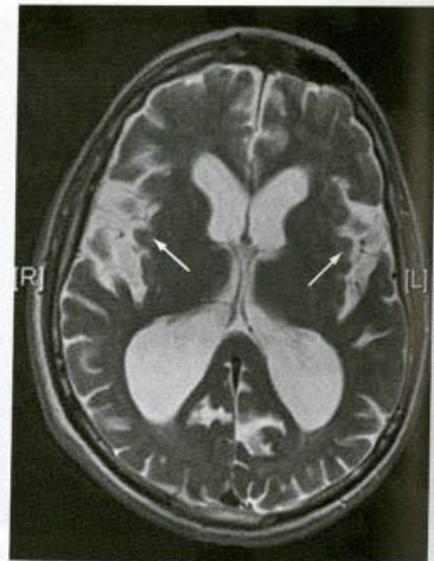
Patient with normal-pressure hydrocephalus and enlarged perisylvian fissures (arrows) without generalized atrophy—T2-weighted magnetic resonance imaging.
